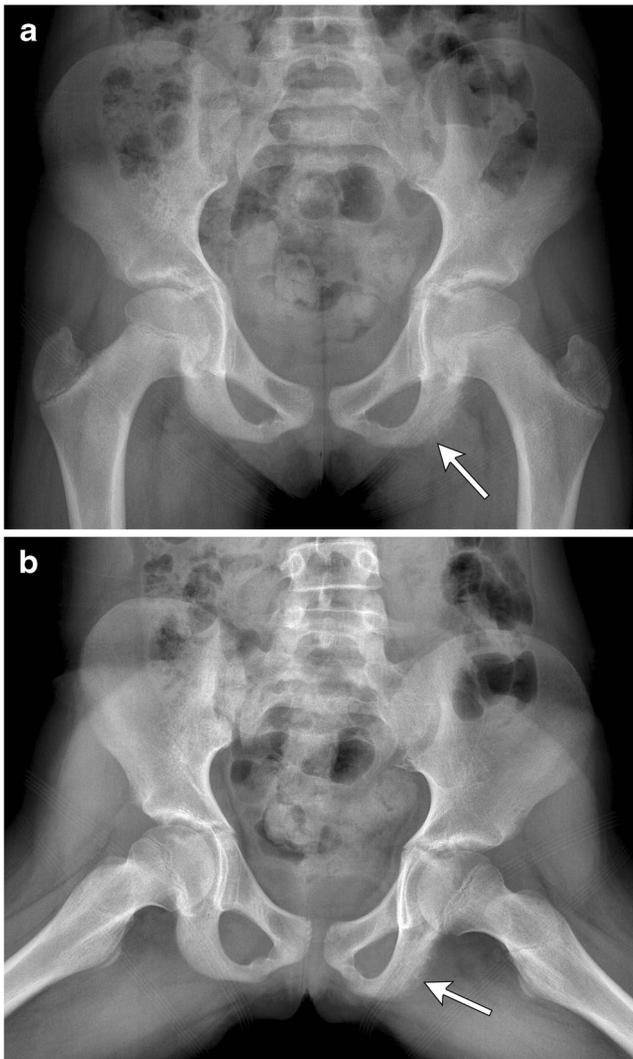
A 12-year-old girl with ischial tuberosity apophysitis presenting as left groin pain. a AP pelvic radiograph demonstrating osseous irregularity and early fragmentation at the left ischial tuberosity (*arrow*). b Frogleg pelvic radiograph demonstrating the same findings with left ischial tuberosity osseous irregularity and fragmentation (*arrow*)
